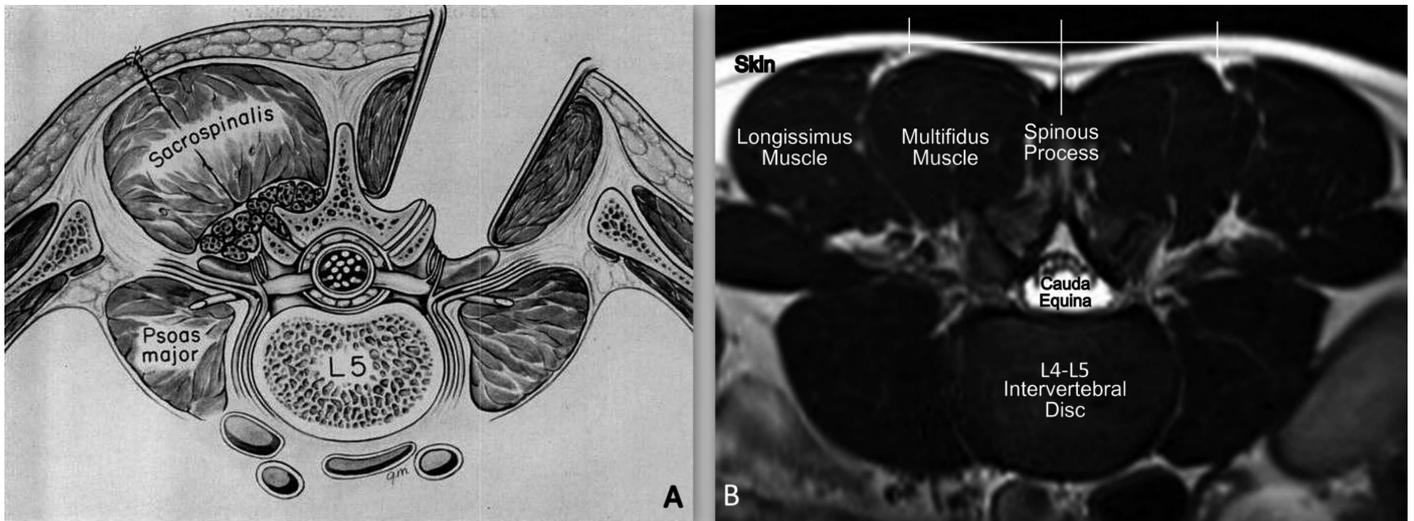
(A) Wiltse’s original approach, as described in 1968. Note that the cutaneous incisions are made directly over the intermuscular cleavage plane. Reproduced with permission from JBJS (www.ejbs.org).¹ (B) Axial MRI view at the level of the L4–L5 intervertebral disc with structures labeled. Measurements were taken between the marked midline and lateral points.
